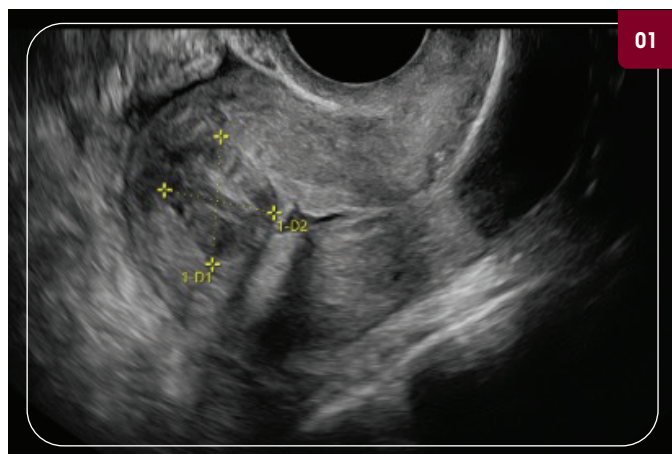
Mid-sagittal transvaginal ultrasound with fibroid measuring 2.0 cm x 1.7 cm.
